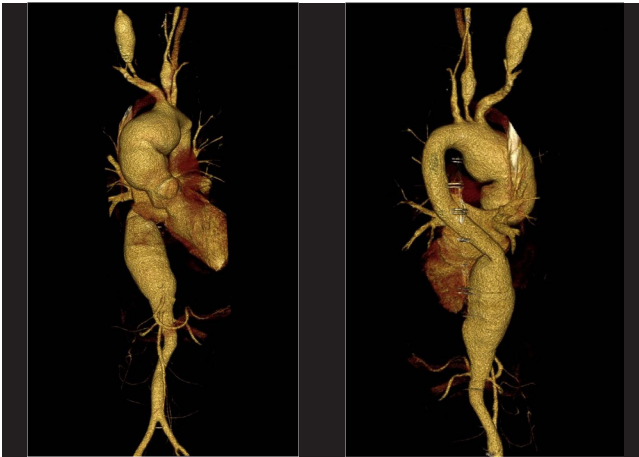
Preoperative 3D reconstructed CTA demonstrated aneurysms in ascending aorta, bilateral common carotid arteries and thoracoabdominal aorta(A,B).
